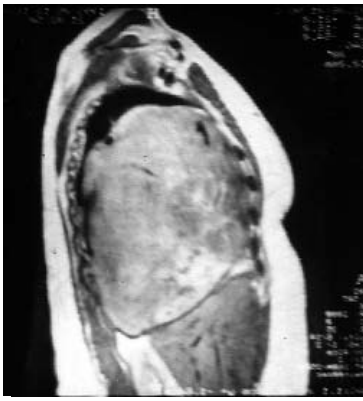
MRI of 2.5kg tumour of the right hemi thorax
